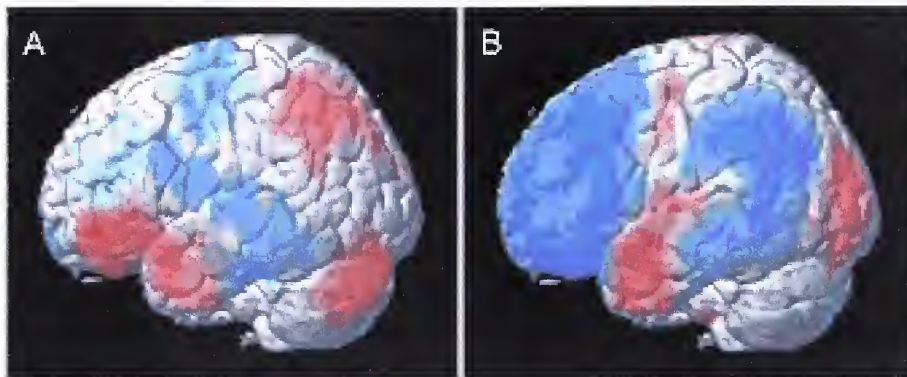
Fronto-parietal excitation in generalized tonic-clonic seizures and fronto-parietal inhibition in complex partial seizures. A. Tonic-clonic seizures causes abnormal cerebral blood flow increases (red) in the bilateral frontal and parietal association cortex. SPECT ictal-interictal difference imaging was obtained from a patient during a generalized tonic-clonic seizure induced by bilateral frontotemporal electroconvulsive therapy stimulation.^A Bilateral cerebral blood flow increases (red) were present in the frontotemporal regions, the parietal cortex, and the cerebellum, with relative sparing, or cerebral blood flow decreases (blue) in intervening regions (left hemisphere only shown here). B. Complex-partial seizure causes abnormal cerebral blood flow decreases (blue) in bilateral frontal and parietal association cortex. SPECT ictal-interictal difference imaging was obtained from a patient during a complex partial seizure arising from the temporal lobe involved in this study. Cerebral blood flow increases were present in the temporal lobe of seizure onset, and marked decreases were present in the frontal and parietal cortex bilaterally (left hemisphere only shown here). Ictal and interictal SPECT images for A and B were acquired and analyzed using SPM. This figure is from, with permission of author, Blumenfeld, H. and J. Taylor, *Why do seizures cause loss of consciousness?* The Neuroscientist, 2003. 9(5).
